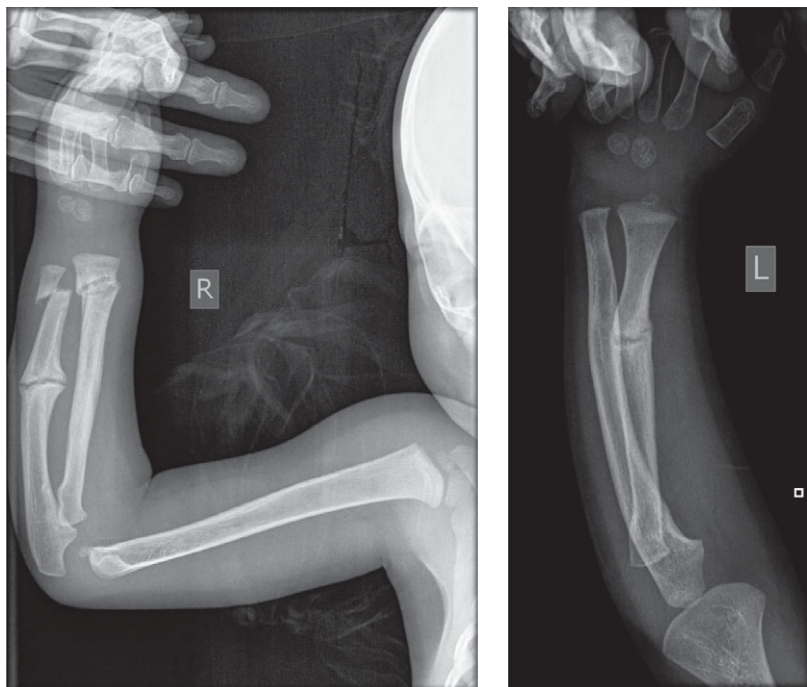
(a) Anteroposterior (AP) radiograph of the right arm and (b) lateral radiographs left forearm
